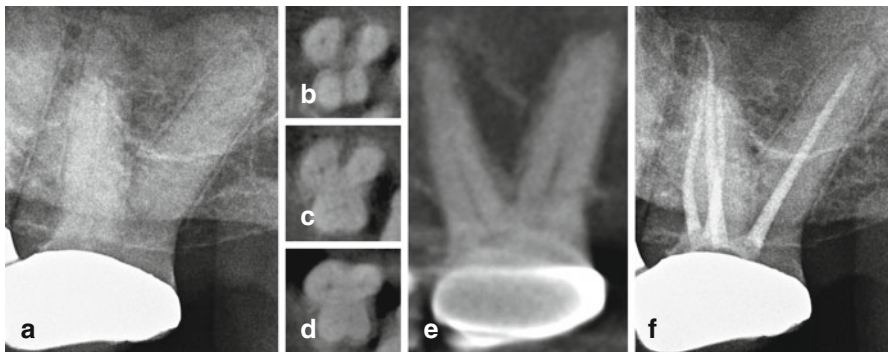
Preoperative periapical radiograph of a maxillary left second molar (a), with corresponding axial CBCT slices captured from the apical third (b), mid-root (c), and coronal third (d) demonstrating four separate canals and a morphologic root division into four separate roots. The sagittal CBCT slice demonstrates two separate palatal roots (e). The post-endodontic periapical radiograph demonstrates all identified root canal systems treated (f)
